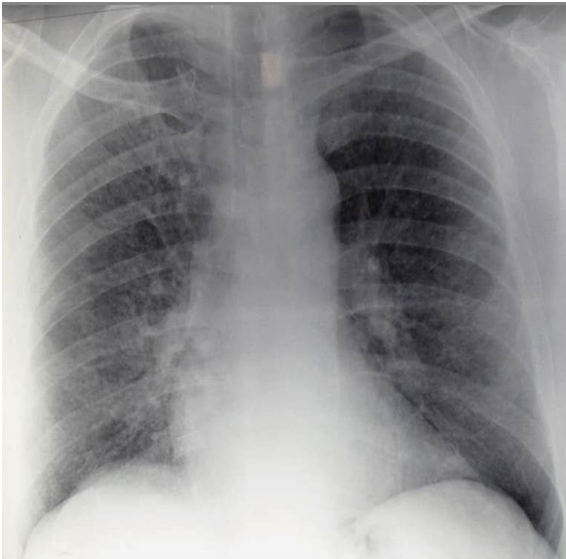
Chest X-ray revealed bilateral interstitial micronodular pattern.
